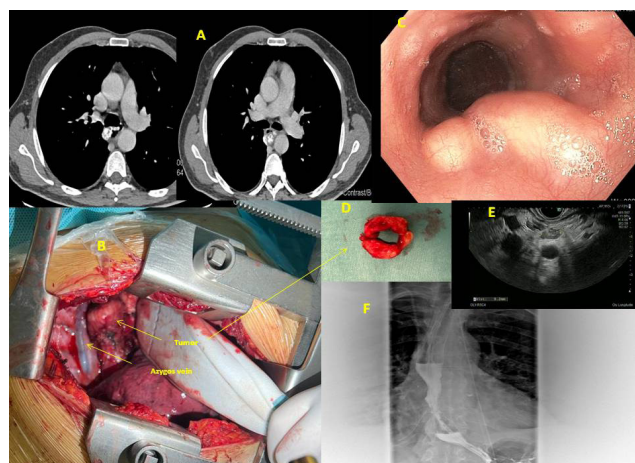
(A) CT pre-operative image of the leiomyoma; (B) Intra-operative image of the tumor; (C) Endoscopic view; (D) Donut-like leiomyoma; (E) EBUS image; (F) gastrograffin swallow control after surgery.
